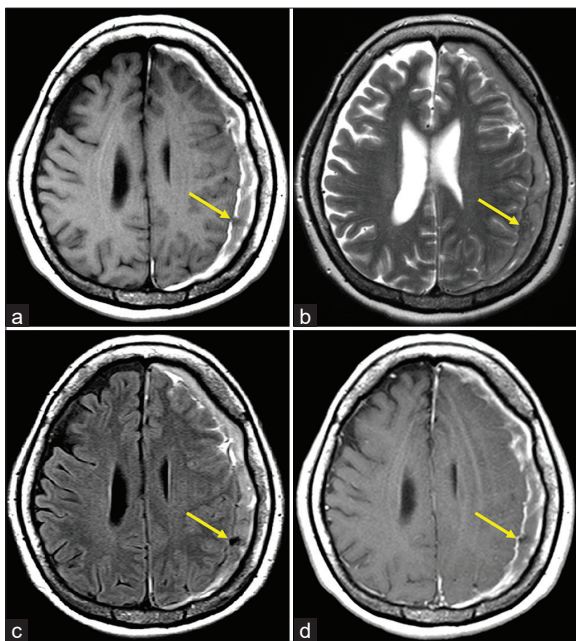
Non-contrast axial T1- (a), T2-weighted- (b), fluid attenuated inversion recovery- (c), and post-contrast axial T1-weighted magnetic resonance imaging (d), performed on post hospitalization day 6, showing a non-enhancing, nodular lesion in the subdural hematoma, adjacent to the left parietal cortex (a-d, arrow).
